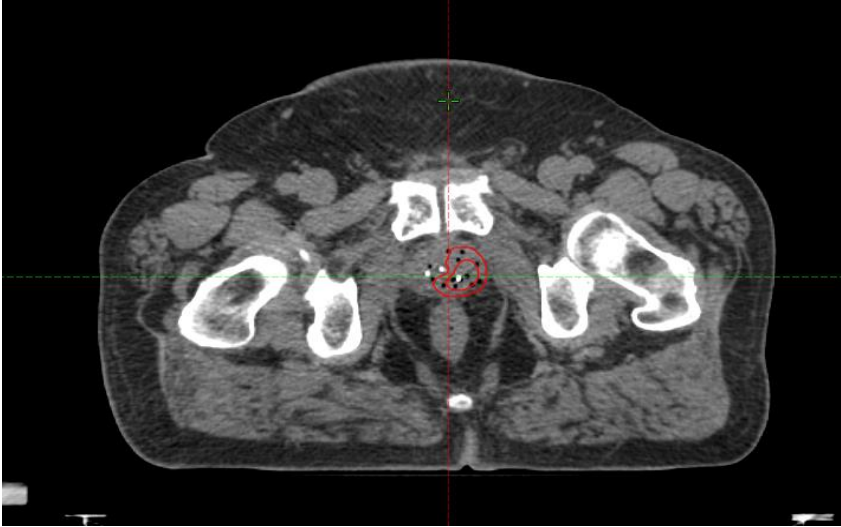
shows the CT contours with inner red line is the GTV and the outer red line is the CTV
